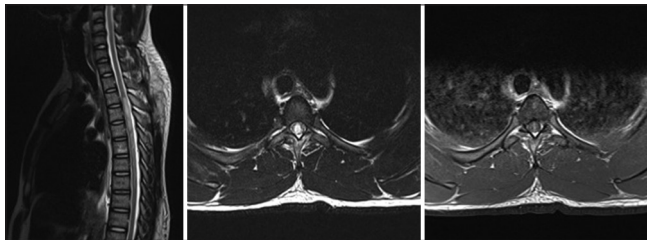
Preoperative MRI, revealing a hyperintense signal of the cord in the D4-D5 region, with a slight and diffuse thickening (Sagittal T2), cetro-medullary (axial T2), showing a modest and diffuse enhancement with Gadolinium
